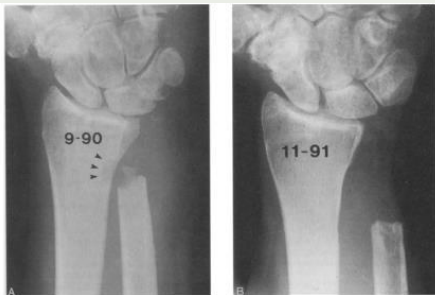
(A) Preoperative x-ray film demonstrating radioulnar impingement, irregularity of the distal ulnar stump, and medial scalloping of the distal radius (arrows). (B) Postoperative x-ray film following salvage of the failed Darrach resection shows maintenance of an improved radioulnar separation, resolution of the scalloped border of the distal radius, and a less irregular contour of the resected distal ulna.
